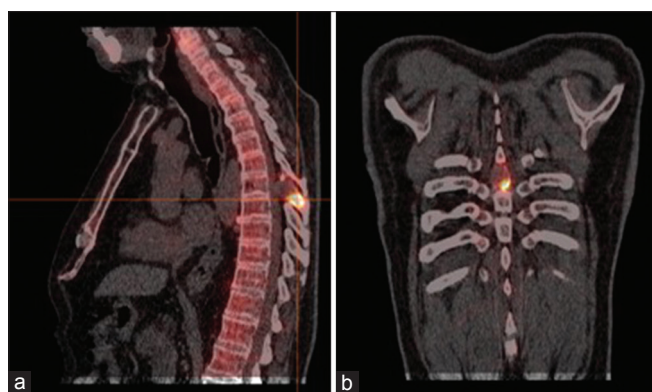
Sagittal (a) and coronal (b) fused single-photon emission computed tomography-computed tomography images showing an area of intense ^{99m}Tc -methylene diphosphonate uptake adjacent to an expansile lytic lesion localized to the spinous process and lamina of T6^[12]
